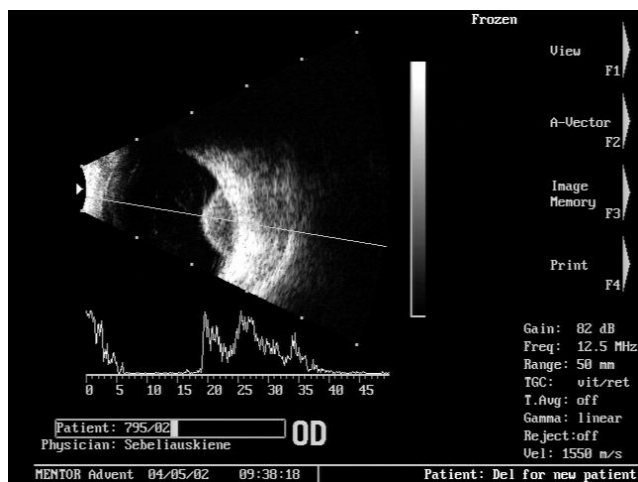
B-scan image of Mentor Advent A/B ultrasound system
